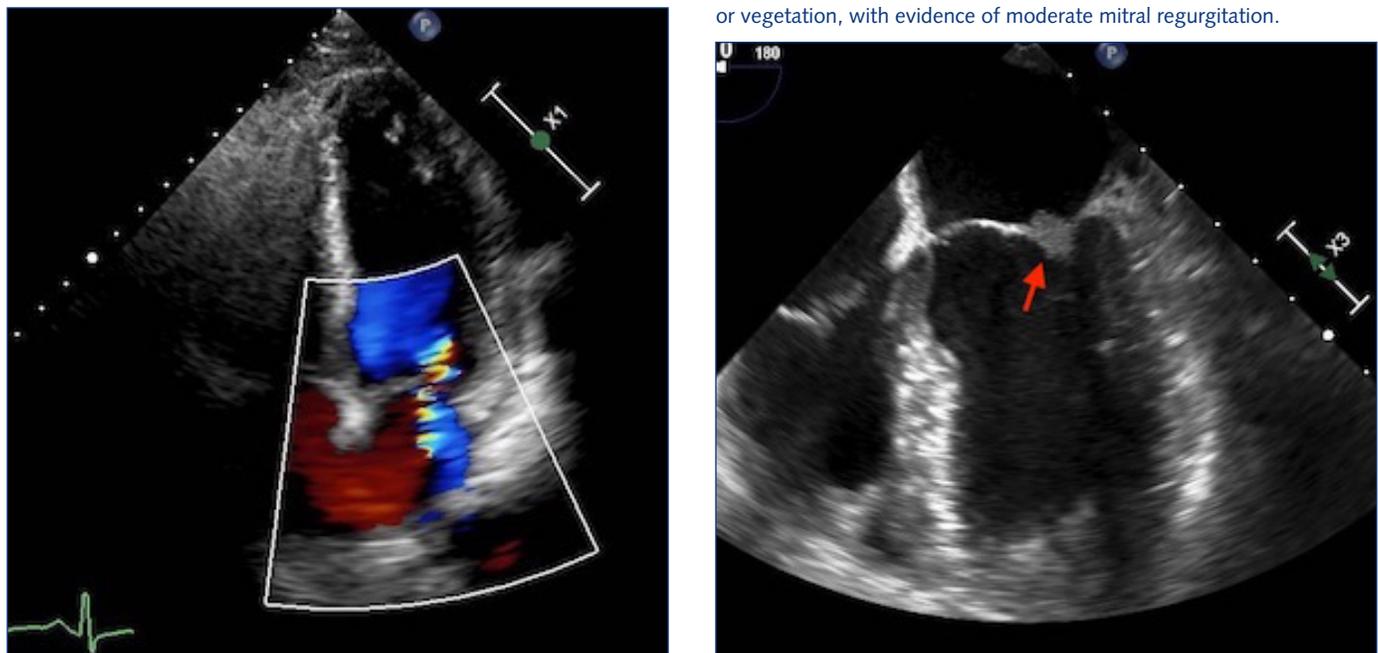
TTE image on index hospitalization displaying thickened mitral valve leaflets, with a restricted posterior leaflet and color doppler evidence of new mitral regurgitation when compared to prior.
